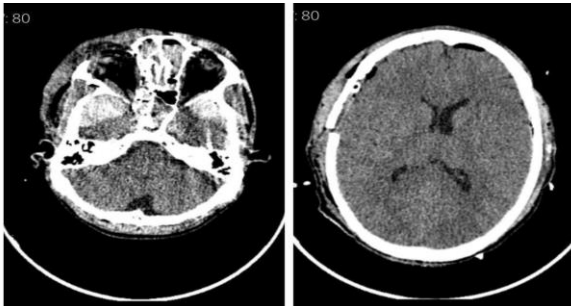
Axial CT Brain shows Bitemporal hematoma.
